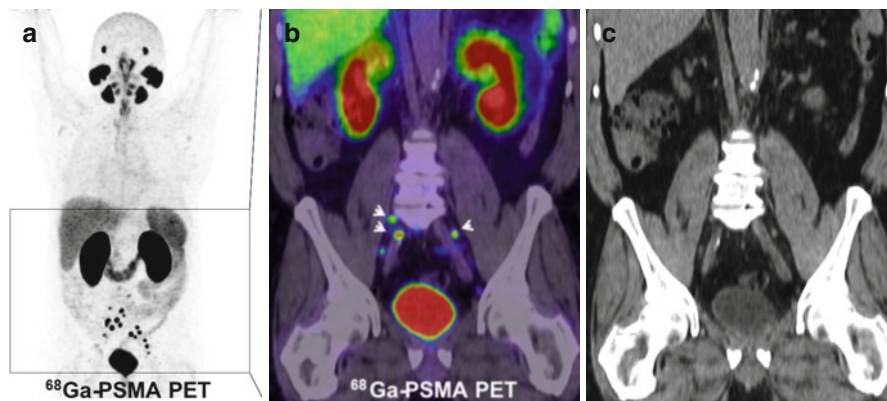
A patient with an elevated PSA serum level as indicator of recurrence of prostate cancer after total prostate resection 3 years ago. Patient was imaged with a recent introduced new small molecule PET tracer called prostate-specific membrane antigen (*PSMA*). (a) Presenting whole-body distribution of $^{68}\text{GaPSMA}$ PET in MIP technique. (b) PSMA is specific and taken up by prostate cancer cells (presenting strong uptake in these lymph node (arrow) in the pelvis region) indicated recurrence of prostate cancer. The coronal CT (c) small lymph nodes close to the ilio-psoas muscle on both sides can be appreciated without suspicious enlargements (<1 cm)
